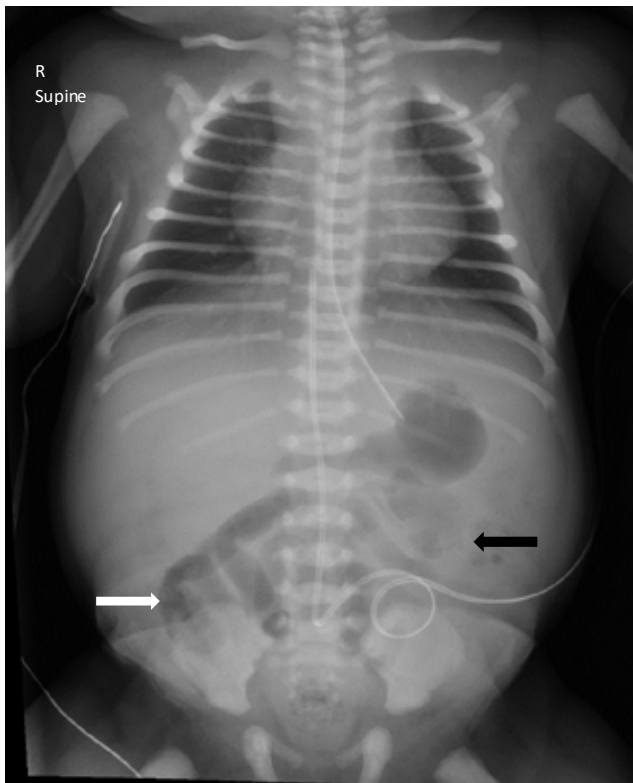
Supine chest and abdomen radiograph showing mild pulmonary interstitial infiltrates, paucity of bowel gas in left hemi abdomen (black arrow) and distension of loops of bowel in the right
